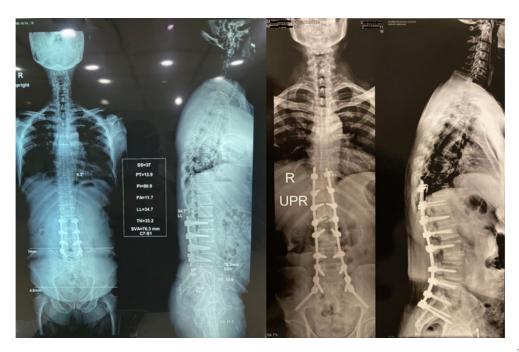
Preoperative (left) and postoperative (right) radiographs of a revision spinal surgery in which this technique was used successfully to retrieve screws
